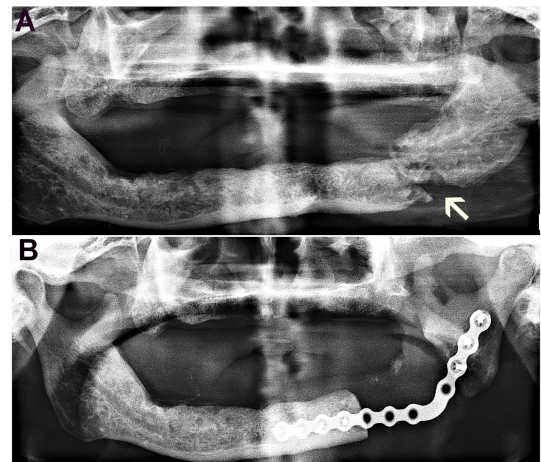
A comparison of pre- and post-operative orthopantomograms (OPGs). (A) Preoperative OPG demonstrating an ill-defined moth eaten radiolucent area located in the left body region of the mandible, with evidence of a pathological fracture as indicated by a step along the inferior border and an upward displacement of the proximal ramal fragment; (B) Postoperative OPG showing a good restoration of mandibular contour and continuity achieved with the help of the Reconstruction plate.
